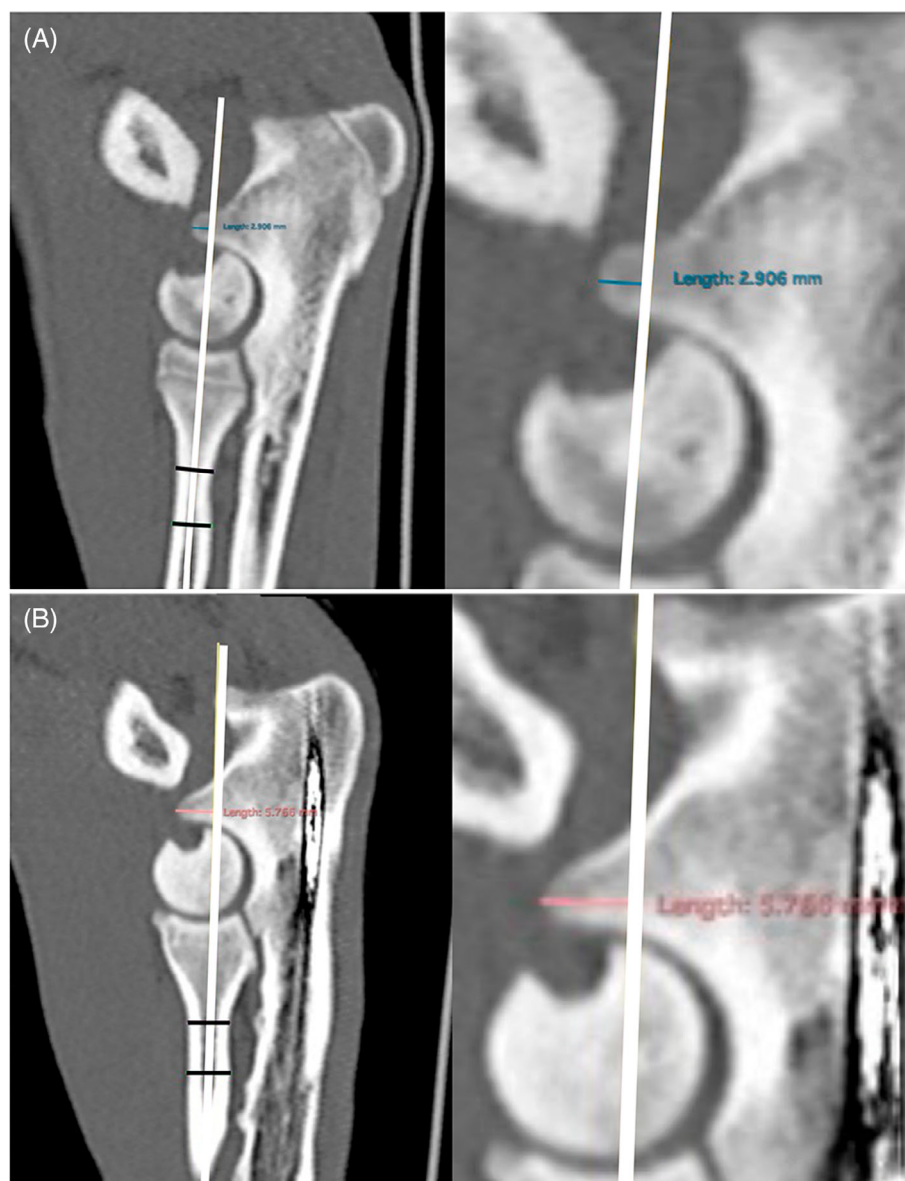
The measurement of the cranial displacement of the tip of the anconeal process in direction of the supratrochlear foramen on preoperative (A) and follow-up (B) computed tomography (CT) scans. On sagittal images, the width of the proximal radius was measured in two points and a line intersecting the exact midpoint of these two lines was drawn. A second perpendicular line was drawn from the tip of the anconeal process to the point where the first line intersected the anconeal process (A1 and B1). The distance between the tip of the anconeal process and the first line was then measured in millimeters (A2 and B2).
